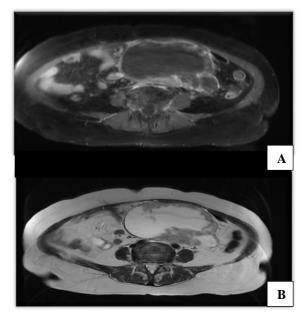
(A) MRI-T, weighted (SE 2000/20) image; and (B) inversion recovery (2000/60; TI=140 msec) image. The change in relative signal intensity of the fatty tumour components follows that of subcutaneous and pelvic fat The fat composition can be detected effectively by using fat suppression techniques that reduce chemical shift artifacts and associated signal drop.
